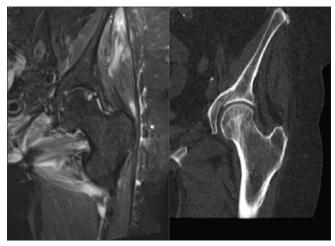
Magnetic resonance imaging (coronal short-tau inversion recovery sequence) was performed due to clinical doubt regarding the computed tomography findings (right) of possible undisplaced fracture at the lateral femoral neck cortex. Magnetic resonance imaging shows a focus of avascular necrosis.
